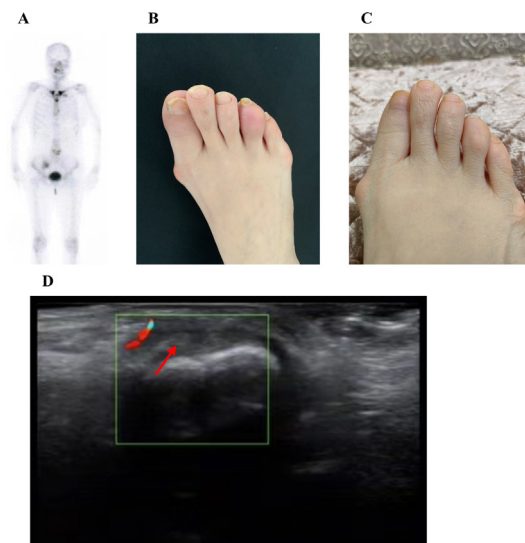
Bone scintigraphy and sausage finger images of the patient with SAPHO syndrome. (A) Technetium 99m-methyl diphosphonate whole body bone scintigraphy showed that abnormal accumulation of radioactivity in bilateral sternoclavicular joints, left sacroiliac joints, bilateral greater trochanters and bilateral ischia. (B) Before interleukin (IL)-17 treatment, the patient’s toes showed sausage finger symptoms. (C) After IL-17 treatment, the symptoms of sausage fingers on the feet of patients were significantly improved. (D) Ultrasound of the foot joints. Red arrow represents localised synovial thickening of the joint.
